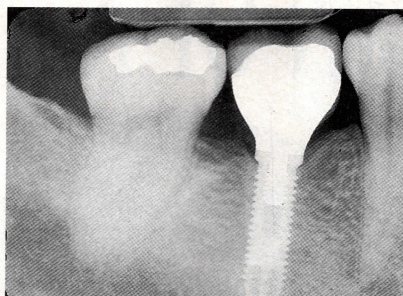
Posttreatment radiograph of the lower right quadrant, showing the placement of a single-tooth implant in restored edentulous space, and the bone crest repair on the mesial of the second molar (compare to Figure 4C). (Implant placement by Dr. Dennis Tarnow, New York, NY.)
